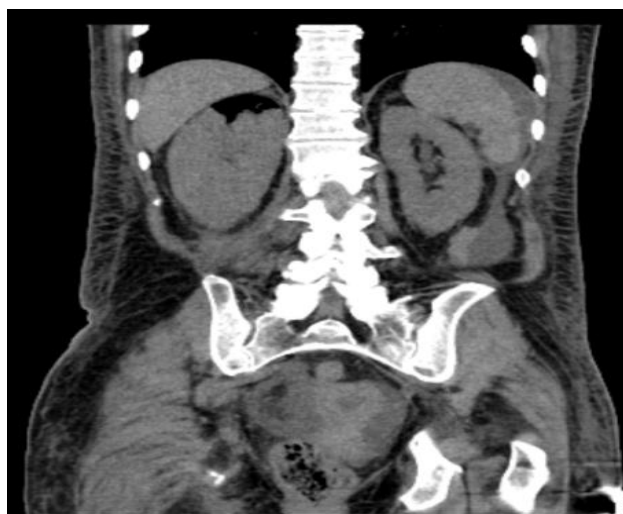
CT (control) with contrast with evidence of free gas resorption in the area of the right kidney
